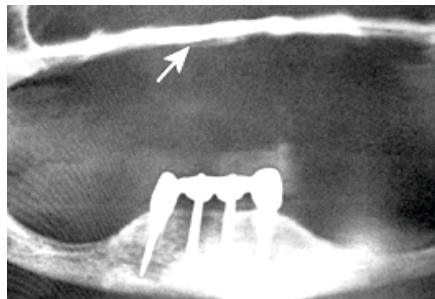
33 Radiographic image showing Dental implants placed in alveolar bone
